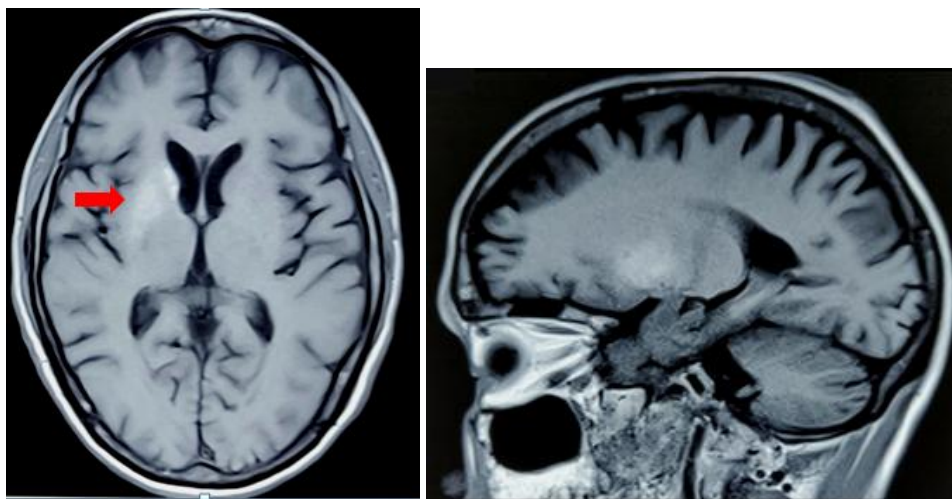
(a) T1 weighted axial and 2(b) T1 weighted sagittal MRI brain images show hyperintensity in right caudate and right lentiform nucleus.
